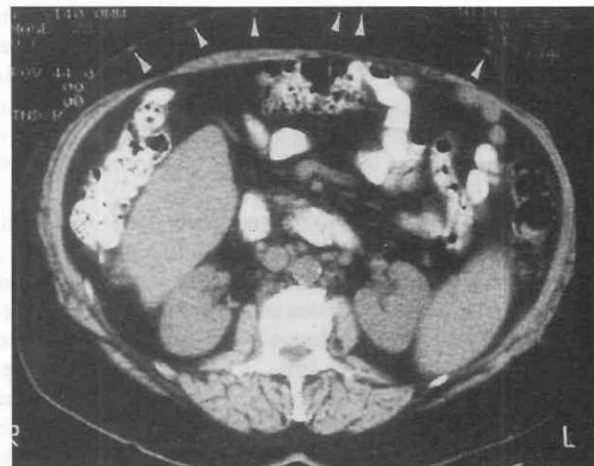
Collateral vessels mimicking "borderline"-sized to mildly enlarged lymph nodes in a patient with upper abdominal inferior vena cava occlusion. Unenhanced CT scan also demonstrates the presence of subcutaneous collateral vessels (arrowheads).
